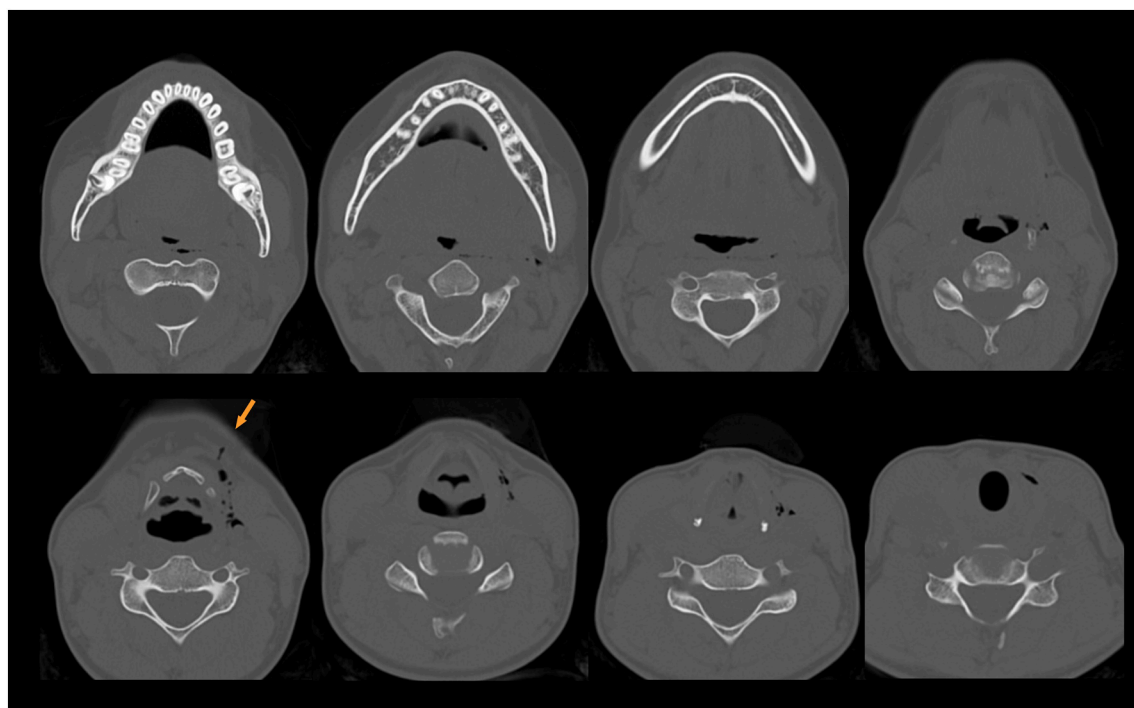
Serial computed tomography images of the cervical region.
